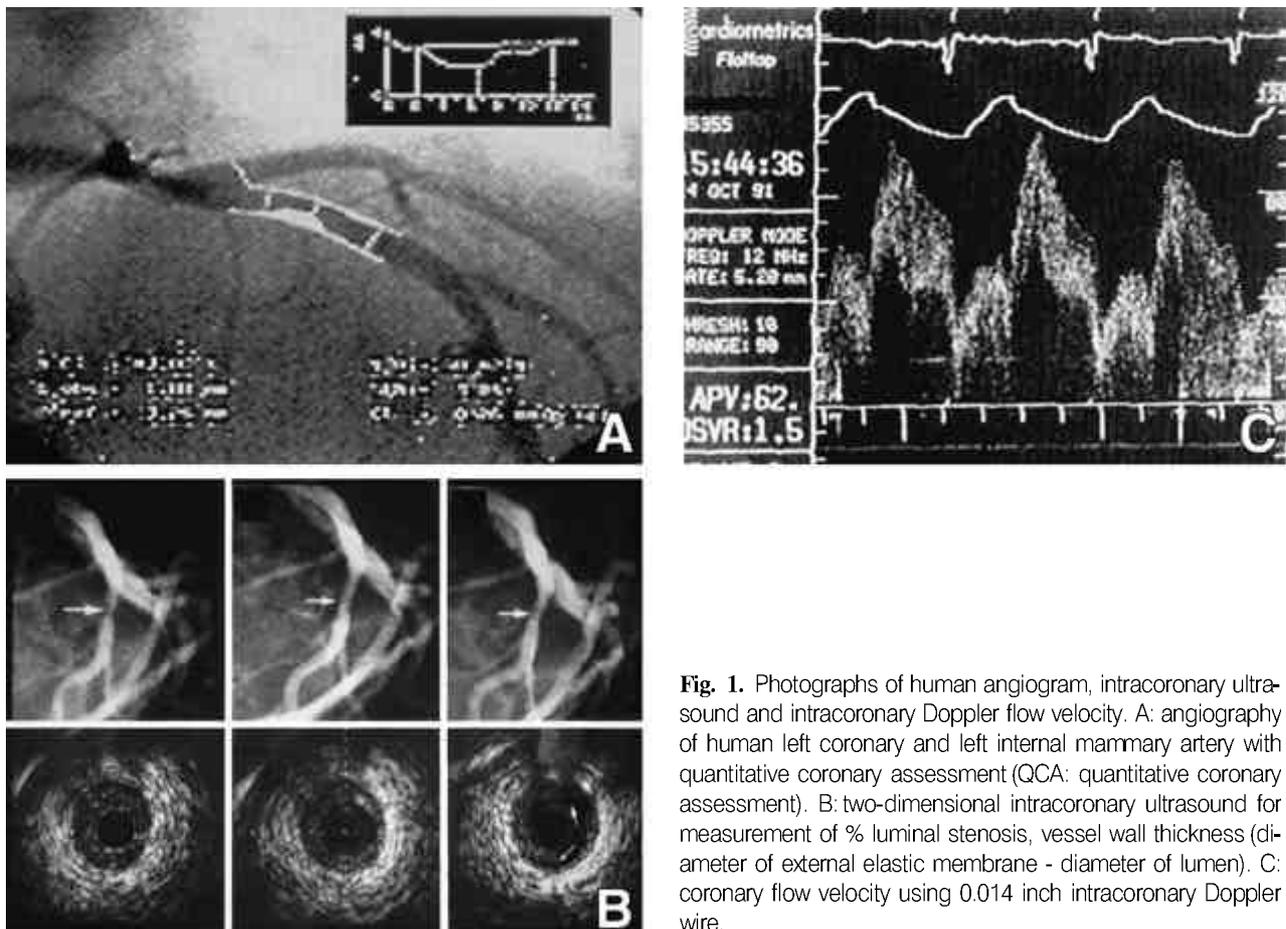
Photographs of human angiogram, intracoronary ultrasound and intracoronary Doppler flow velocity. A: angiography of human left coronary and left internal mammary artery with quantitative coronary assessment (QCA: quantitative coronary assessment). B: two-dimensional intracoronary ultrasound for measurement of % luminal stenosis, vessel wall thickness (diameter of external elastic membrane - diameter of lumen). C: coronary flow velocity using 0.014 inch intracoronary Doppler wire.
